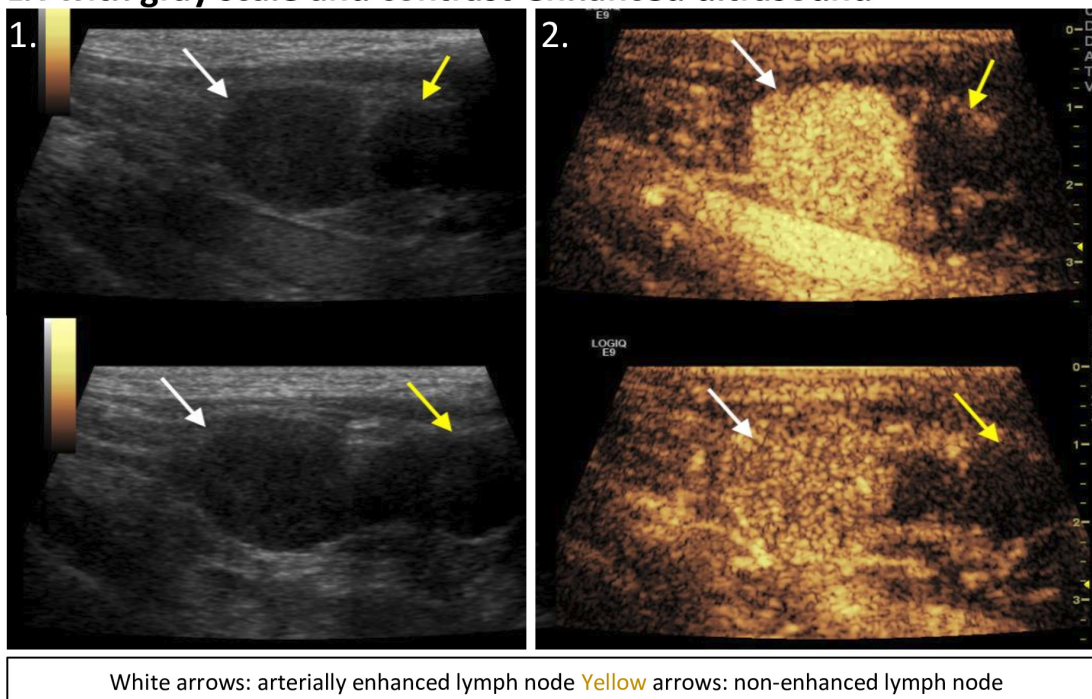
Variables affecting injection technique. (A) Ultrasound images demonstrating vascularity of a tumor-containing LN. (B) Liver metastasis with gray scale (B1) and contrast-enhanced (B2) ultrasound revealing hypervascularity relative to liver parenchyma. (C) Liver metastases with extensive internal necrosis. (D) LN with gray scale and contrast-enhanced ultrasound. Gray scale (D1) and contrast-enhanced (D2) ultrasounds of a subcutaneous LN demonstrating an arterially enhanced, without parenchymal washout, LN (white arrows) and a non-enhanced, likely necrotic LN (yellow arrows). LN, lymph node.
